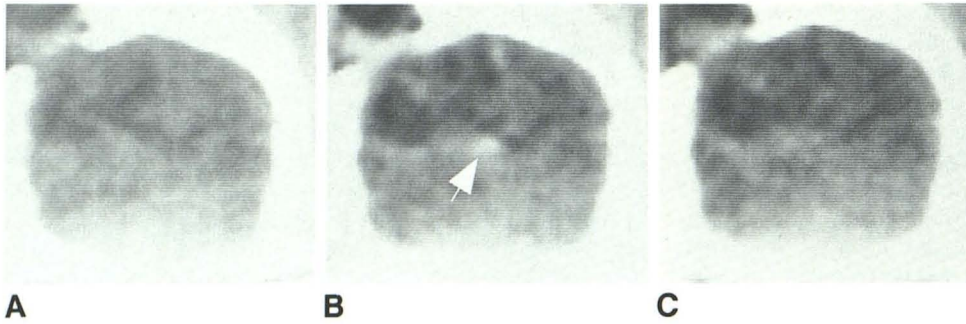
Serial CT scans (A, precontrast; B, 10 min postinfusion; C, 60 min postinfusion) of a staphylococcal abscess 3 days after inoculation. The area of cerebritis is seen as a large, low-density lesion with faint peripheral contrast enhancement that does not form a complete ring. Note the already prominent asymmetrical enhancement of the ipsilateral choroid plexus (B, arrow). This latter finding indicated early ventriculitis.
